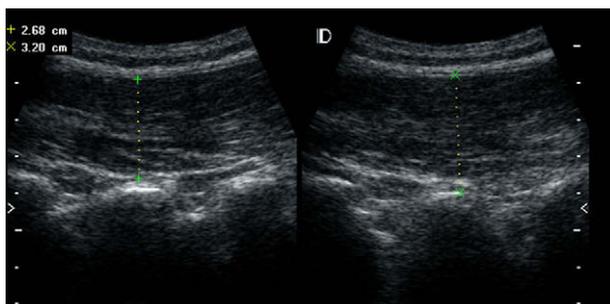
Ultrasound image of the multifidus muscle in parasagittal section at rest and on contraction using a split-screen. Relaxed multifidus muscle thickness = 2.68 cm, contracted value = 3.20 cm.
